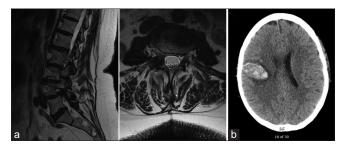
(a) T2-weighted MRI lumbar spine sagittal and axial views demonstrating right L3-4 foraminal stenosis and Grade I anterolisthesis of L4 on L5. (b) right frontal intraparenchymal hematoma noted on immediate postoperative CTH.
